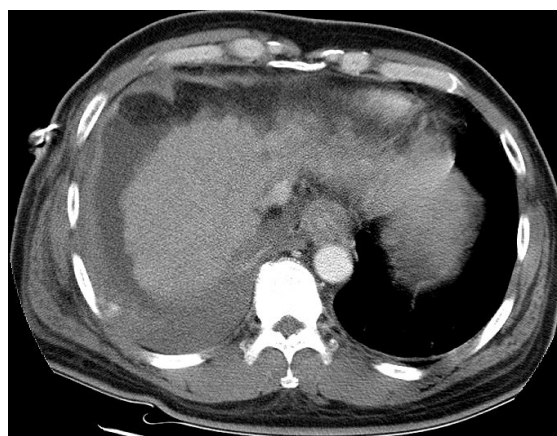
CT scan shows contrast leakage into right pleural space around the junction between posterior and lateral arc of 10th rib.
